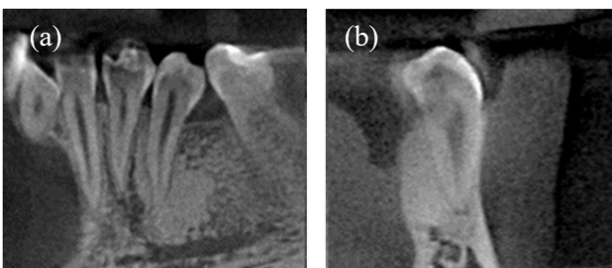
Case 2: Sagittal plane (a) and coronal plane (b) views of CBCT in area of osteosclerotic lesion
